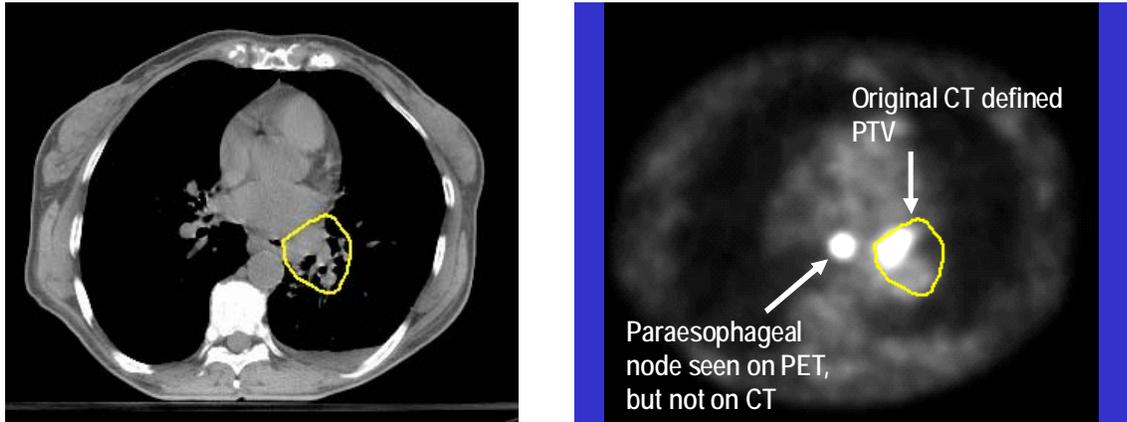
Registered CT (left) and PET images (right) of a mediastinal lung lesion.
